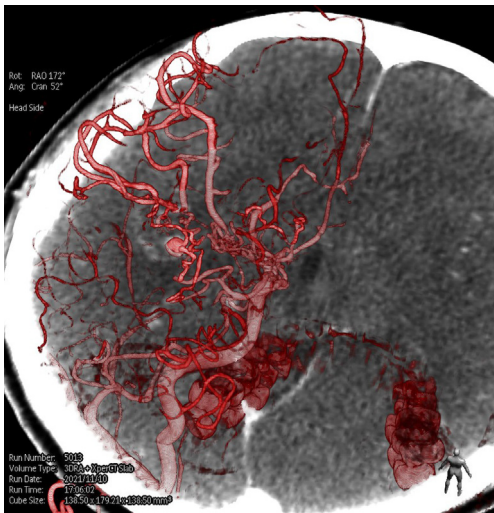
Three-dimensional DSA combined with CT determined the location of the responsible peripheral aneurysms. DSA, digital subtraction angiography; CT, computed tomography.
